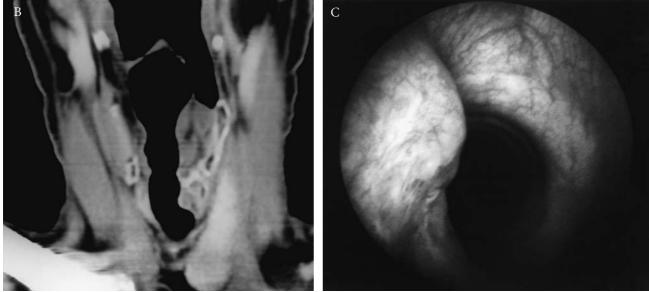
Chondrosarcoma of larynx. A, Cervical computed tomography (CT) scan showing the low-grade tumor invading the laryngeal wall, notably the left cricoid cartilage, in a 64-year-old man. Calcification is notable in the tumor. Treated by laryngoplastic resection and reconstruction. B, CT reconstruction showing the extent of tumor. C, Bronchoscopic view of the same tumor. The tumor is covered by mucosa. Note tracheal rings distally on the right.
